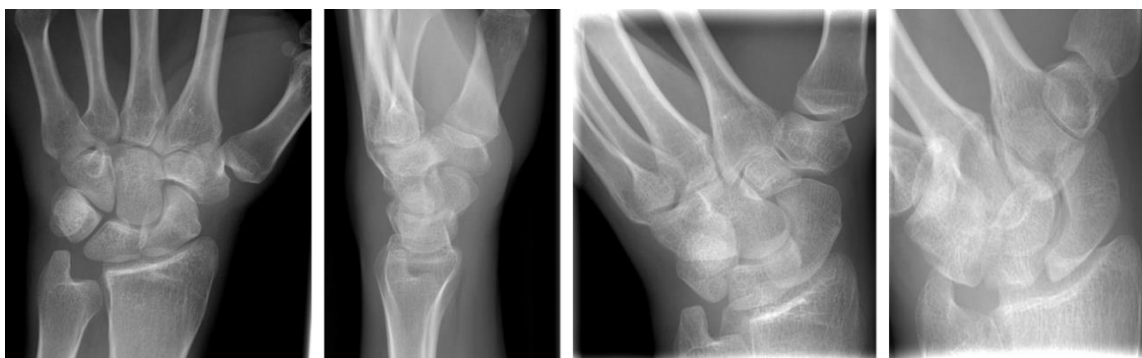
4-view scaphoid initial radiographs at the ED showing no evidence of a scaphoid or any other bone fracture. Hence, the participant was deemed eligible for the SMaRT trial.
